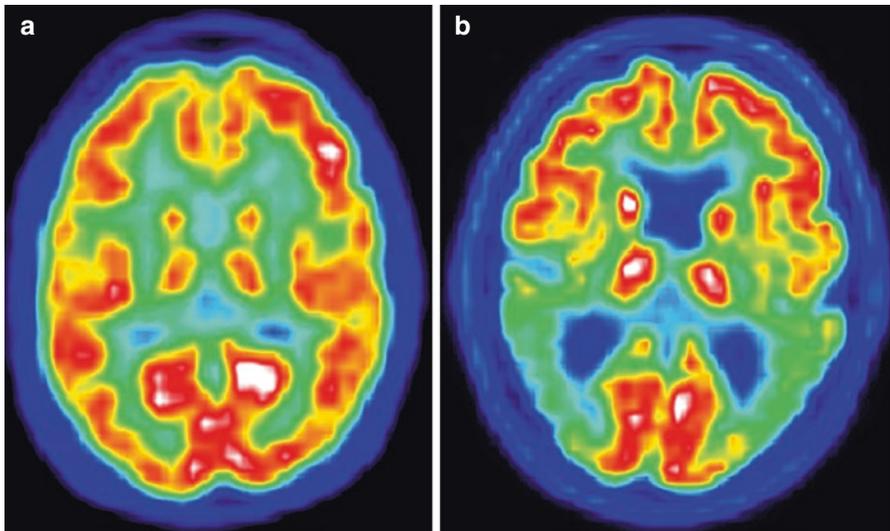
FDG PET. (a) Normal; (b) abnormal with reduced temporo-parietal metabolism characteristic of AD
